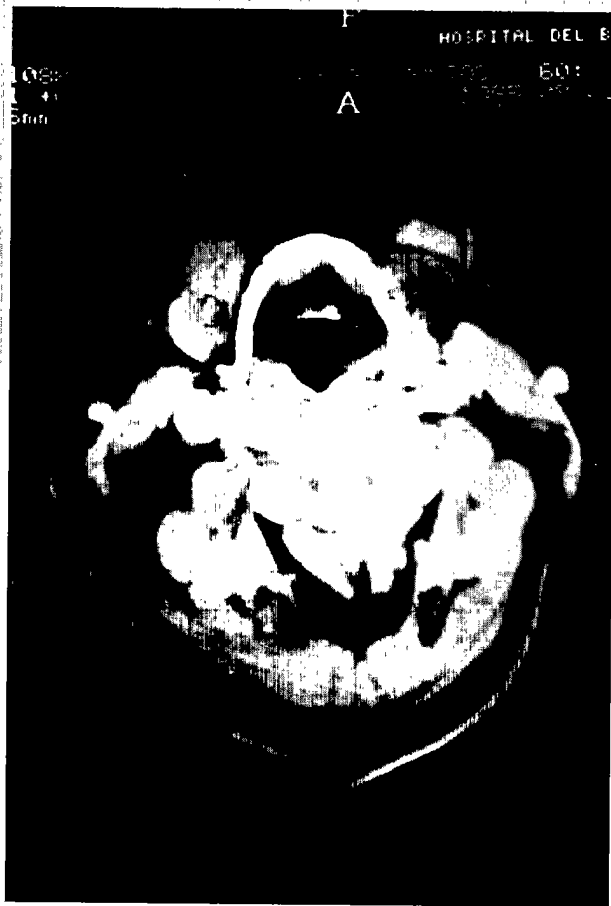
Computed tomography showed a mass adjacent to hyoid bone.
